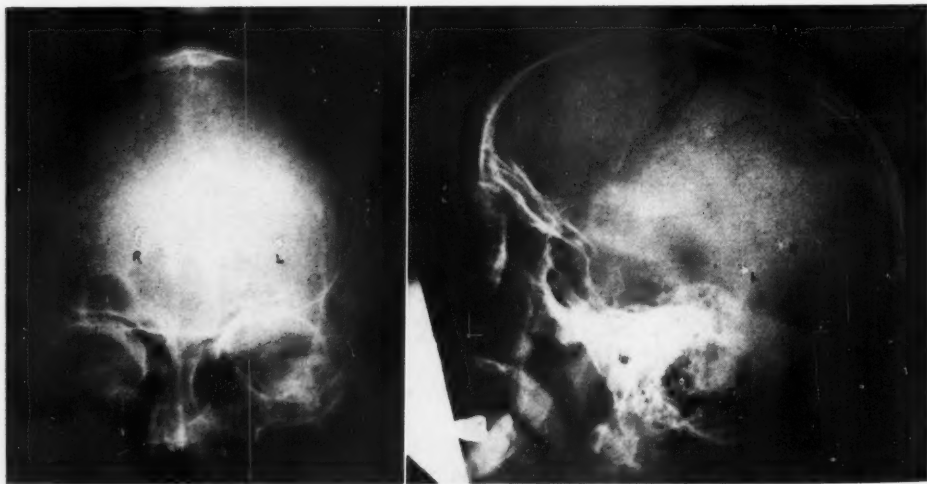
Case 5. 85,297. J. S. Right posterior cerebral tumor verified by ventriculography in a male subject 54 years of age. Convulsions were explained on basis of acute alcoholism. Alcoholic hallucinosis on first admission. No clinical localizing signs of brain tumor. Discharged from hospital without roentgen examination of the skull.
